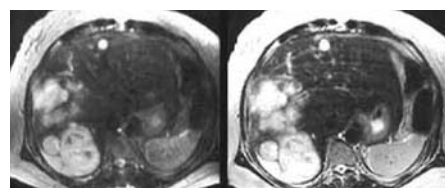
T2-weighted SE (TR 2500, TE 80) left and FSE (TR 4100, TEef 102) right images have different image contrast. The FSE image has greater fat and spleen signal and is somewhat more T2-weighted, due to a longer TR.
